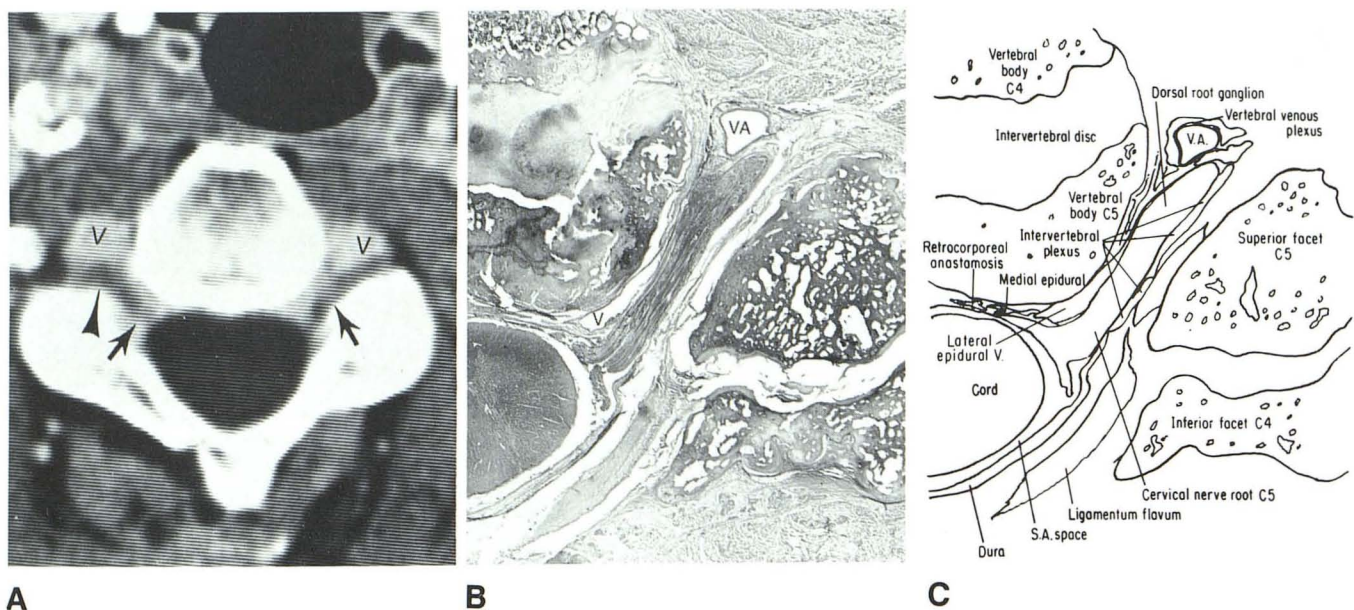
Cervical nerve roots exiting from dura and passing through intervertebral foramen. A, CT scan after bolus, high-volume contrast enhancement. Enhancement of venous plexus surrounding cervical roots. Nerve root is linear hypodensity running through foramen (arrows). Slight widening of root (arrowhead) as it passes behind vertebral artery (V) is the dorsal root ganglion. Venous enhancement between vertebral body and ventral dura. B, Anatomic section through plane of exiting nerve root. Empty space (V) surrounding nerve
